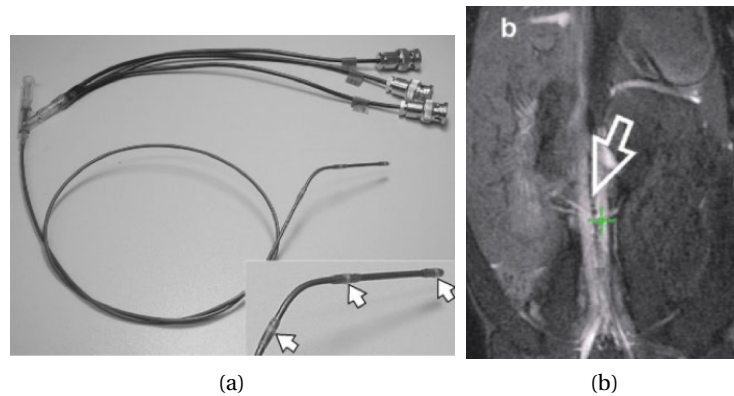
Catheter tracking with RF coils. (a): Catheter with three integrated RF coils connected via coaxial cables to the MRI receiver unit. (b): In-vivo tracking experiment using an active catheter with one coil (green cross). Reprinted from [BVZ<sup>+</sup>04].
